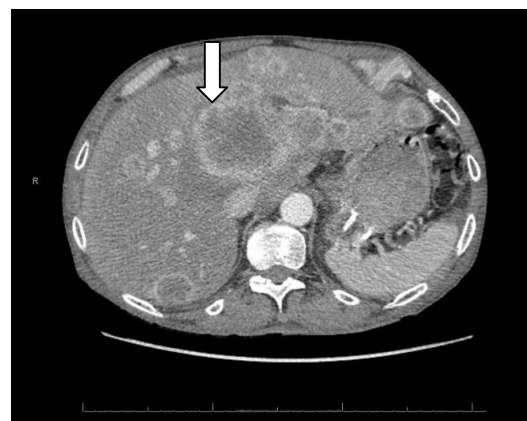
CT scan of the chest and abdomen showing multiple liver lesions
